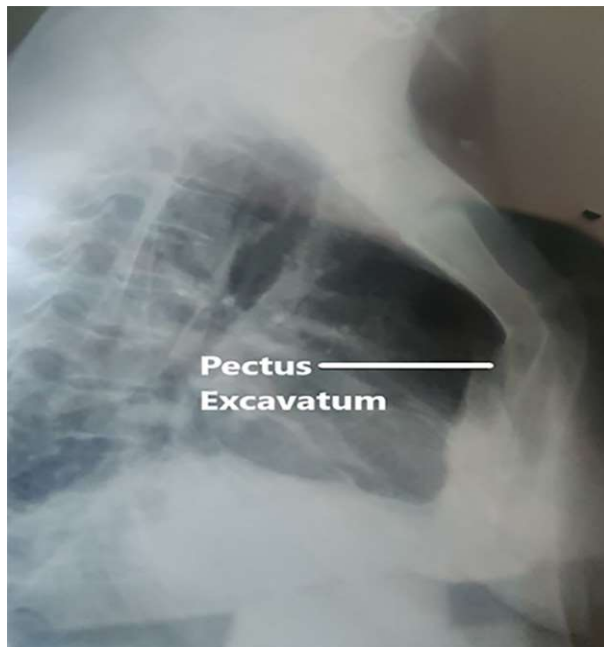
Lateral view of chest radiograph showing pectus excavatum
